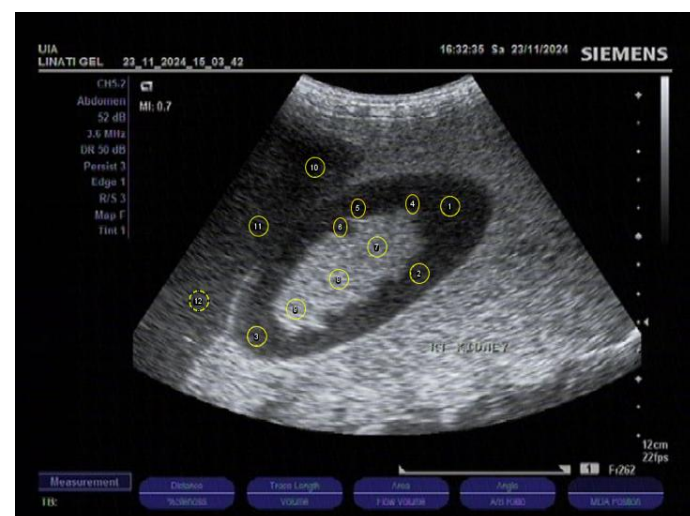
Ultrasound Image of the Kidney with ROI Markings
